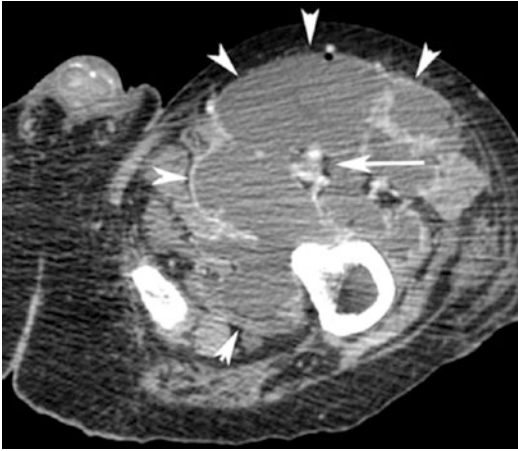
Post-contrast CT axial scan of the left lower limb shows quadriceps muscle large multiloculated collection corresponding to abscess (*arrowheads*), surrounding the femoral vein that contains a thrombus (*arrow*)
